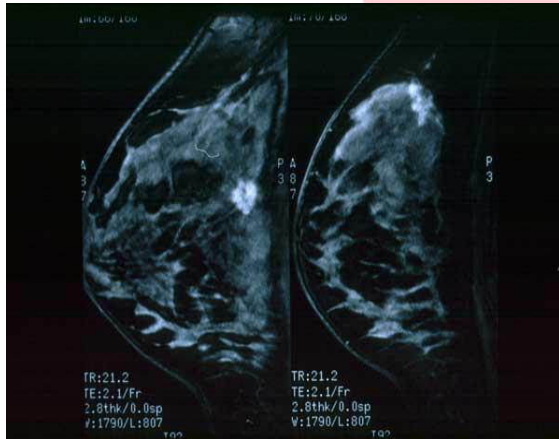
MRI scan of the breast reveals two discrete areas of abnormality, which proved to be cancer.
